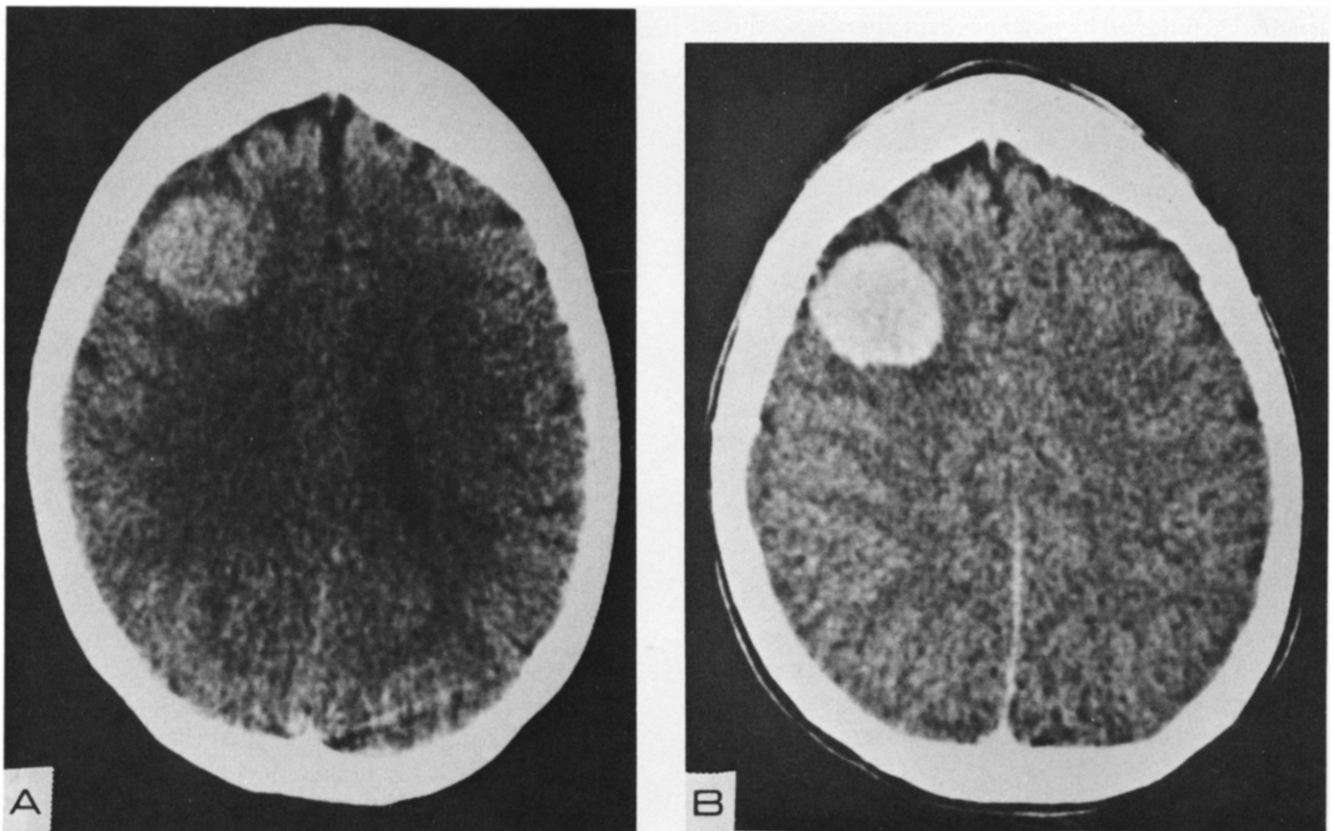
(A) Plain axial CT scan shows a slightly hyperdense mass in the right frontal lobe. (B) After injection of contrast medium, a discrete uniformly enhancing lesion is evident.
